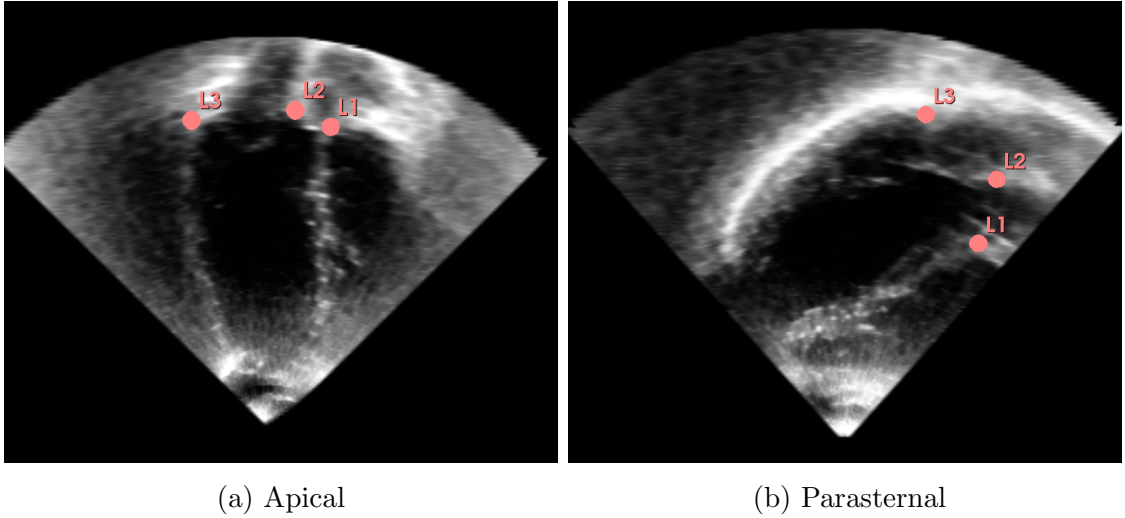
End-diastolic frames of apical and parasternal 3D volumes with manually annotated landmark points. The first point (L1) was picked where the right coronary cusp attaches to the aortic root annulus in PSLAX. The second (L2) and third (L3) points were selected at the anterior and posterior mitral valve leaflet attachment on the mitral valve annulus in the PSLAX, respectively.
